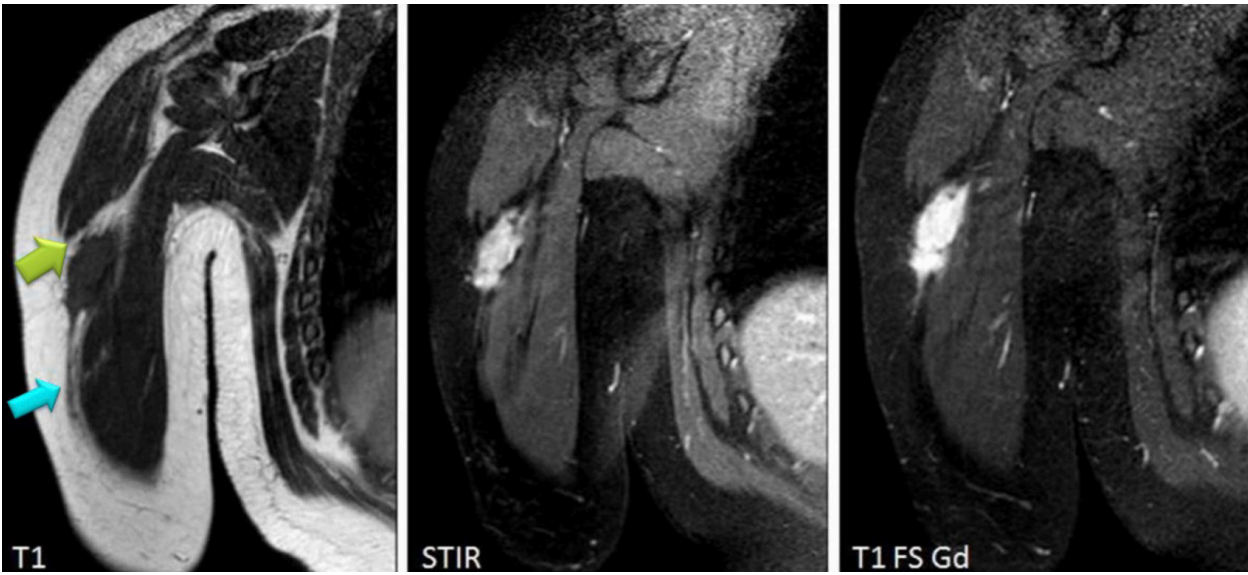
Aggressive fibromatosis in the right upper arm in a 42-year-old female. The lesion is centered in an intermuscular location showing hypointense signal on T1-weighted images, hyperintense signal on fluid sensitive sequences (STIR) and avid gadolinium enhancement. It shows rim of fat (“split-fat” sign, green arrow) and linear extension along fascial planes (“the fascial tail sign”) (blue arrow).
